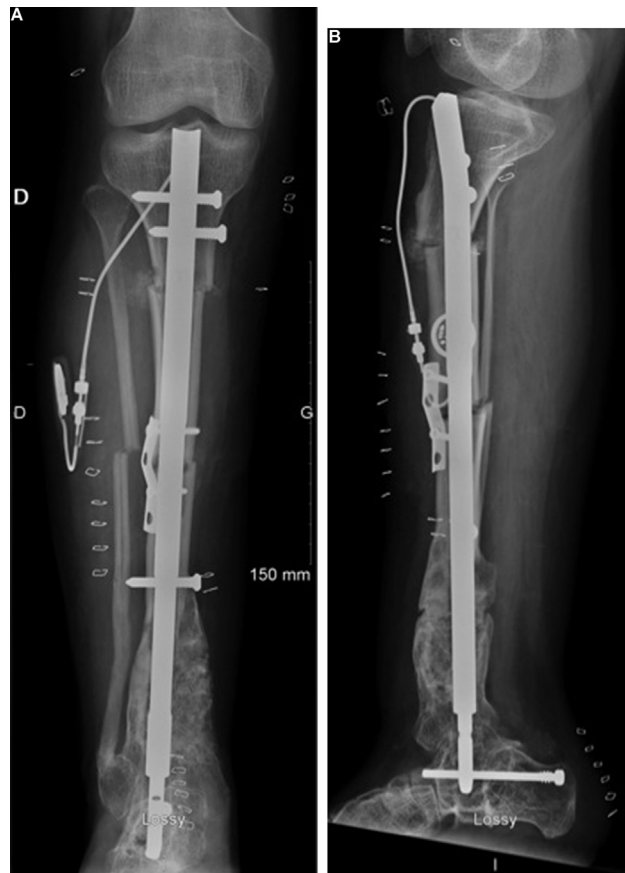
Postoperative radiographs after distraction osteotomies and rotational realignment via a motorised nail.
